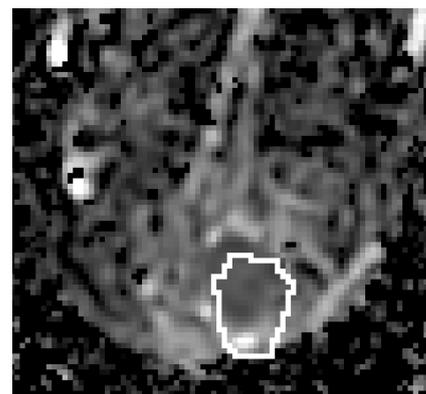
Example of lesion with overlaid boundary mask from DCE-MRI
